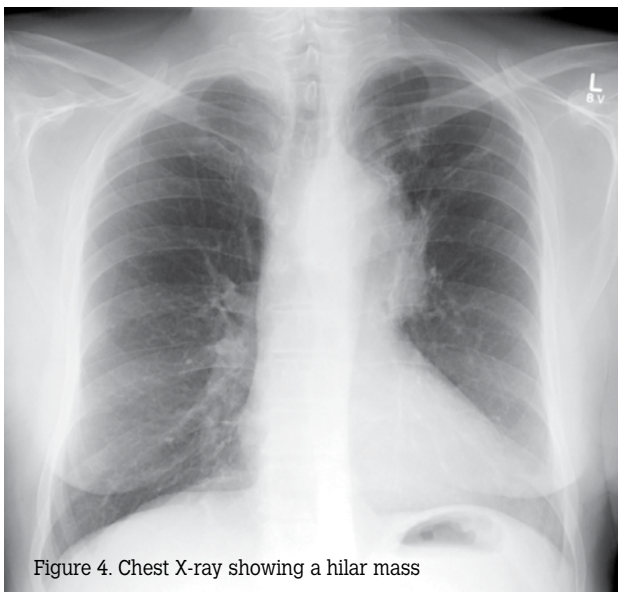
Chest X-ray showing a hilar mass
